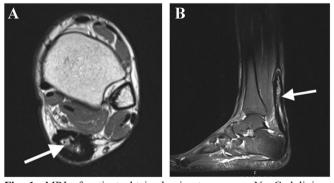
MRI of patient obtained prior to surgery. No Gadolinium contrast was used. a Axial proton density image of ankle showing high signal in Achilles (arrow) indicative of degeneration and poor quality tissue. b Sagittal fat-suppressed, proton density image of Achilles indicating an approximately 10 cm area of poor remodeling (arrow) extending up to the musculotendinous junction.
